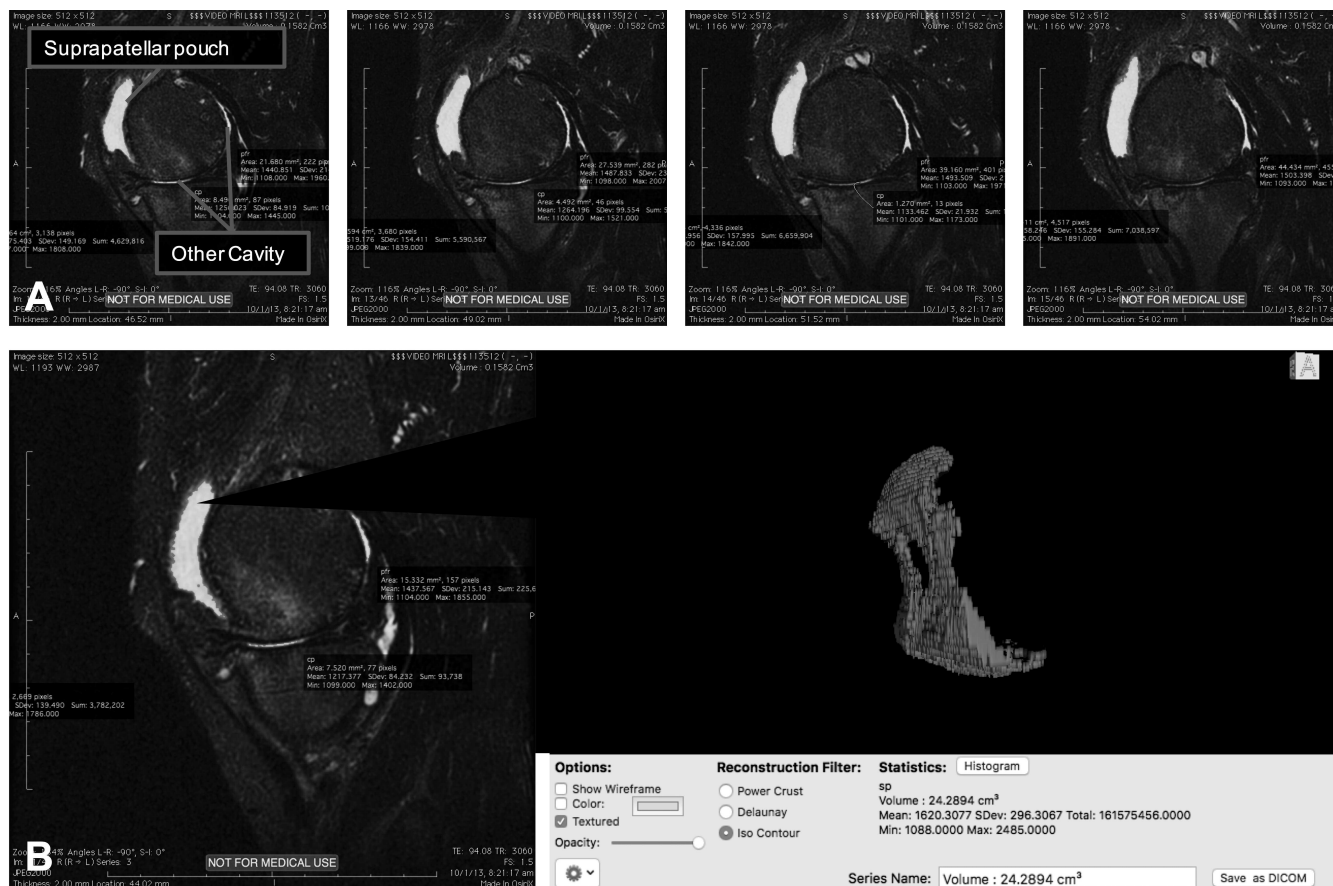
Magnetic resonance images acquired from the knee, with superimposed color data showing the area of fluid-equivalent hyposignals. (A) Representative sagittal image examples were selected from the consecutive slices. The total volume was generated from the highlighted areas (suprapatellar pouch and other cavity) in the entire series of images using OsiriX software. (B) An example of 3-D reconstruction of segmented suprapatellar pouch effusion-synovitis.
